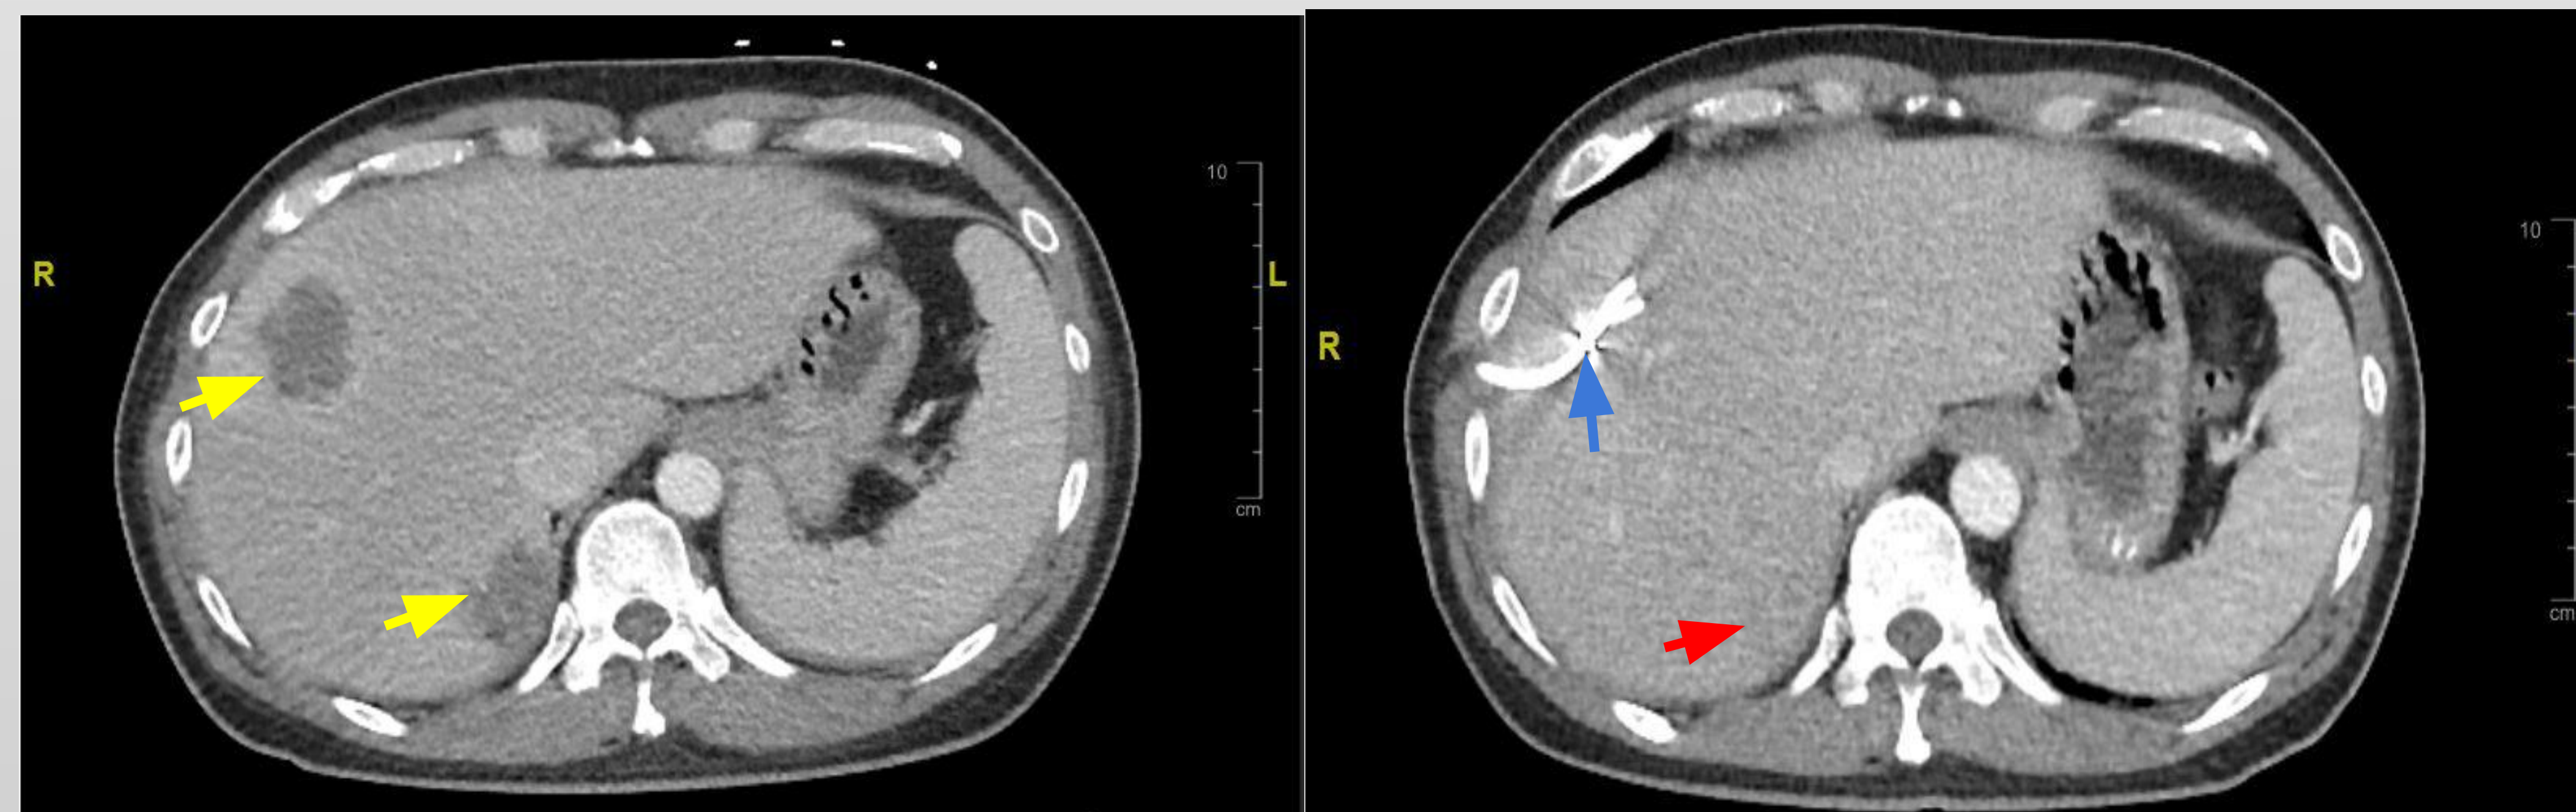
CT abdomen/pelvis on arrival. Note anterior and medial right liver lobe masses (yellow arrows)
